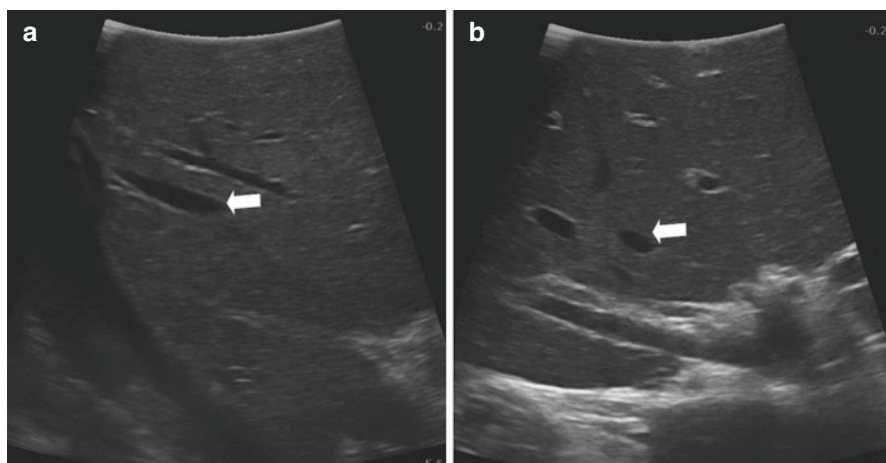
The routine examination order of laparoscopic intraoperative ultrasonography (a) Longitudinal inspection; (b) Horizontal inspection
